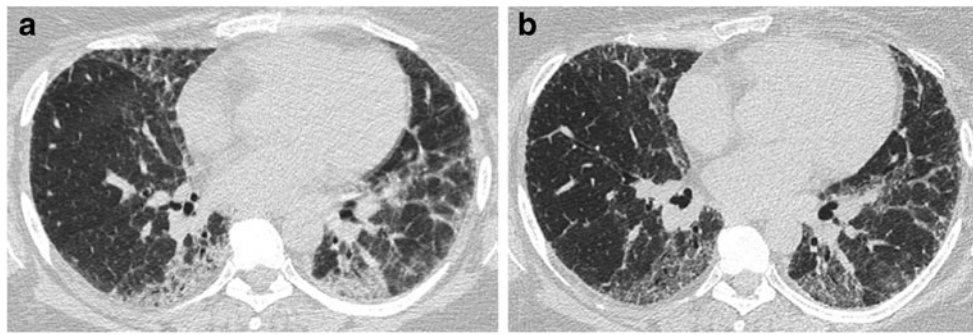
Progressive fibrotic pattern. HRCT images at the same level in a 54-year-old woman with rapidly deteriorating exercise tolerance. a. Shows patchy lower lobe consolidation and a peribular pattern characteristic of OP. b. six months later there is progression to
